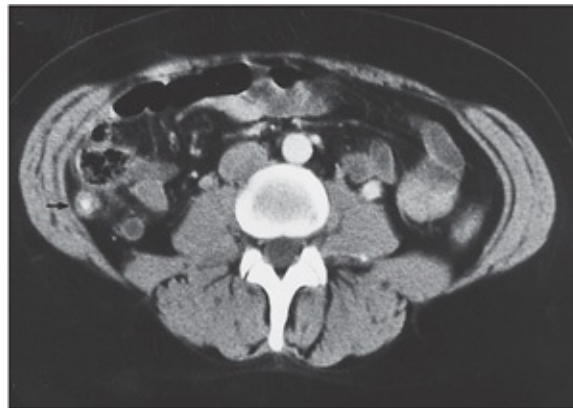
Inflamed appendix on CT (arrow).
